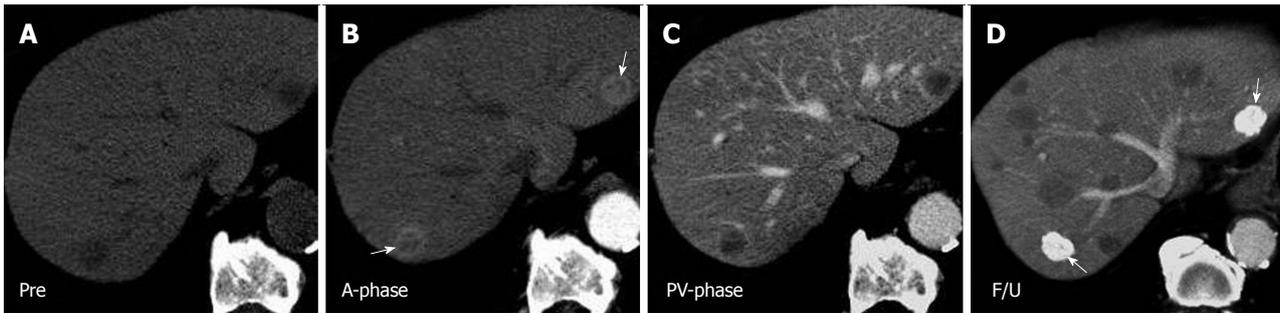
Dynamic enhancing pattern of the liver metastasis from hepatoid adenocarcinoma of the stomach in a 63-yr-old male. A: Liver metastases from hepatoid adenocarcinoma of the stomach presented with hypoattenuation on precontrast computed tomography (CT); B and C: The nodules revealed arterial hyperattenuation (B) and late phase washout (C) on dynamic CT study. Central necrosis (arrows) was found in the small liver nodules; D: The patient received transarterial chemoembolization for liver metastases. The treated liver nodules were well embolized by densely packed Lipiodol (arrows). However, new liver metastases were observed on follow-up CT. Pre: Precontrast; A-phase: Arterial phase; PV-phase: Portal venous phase; F/U: Follow-up image.
